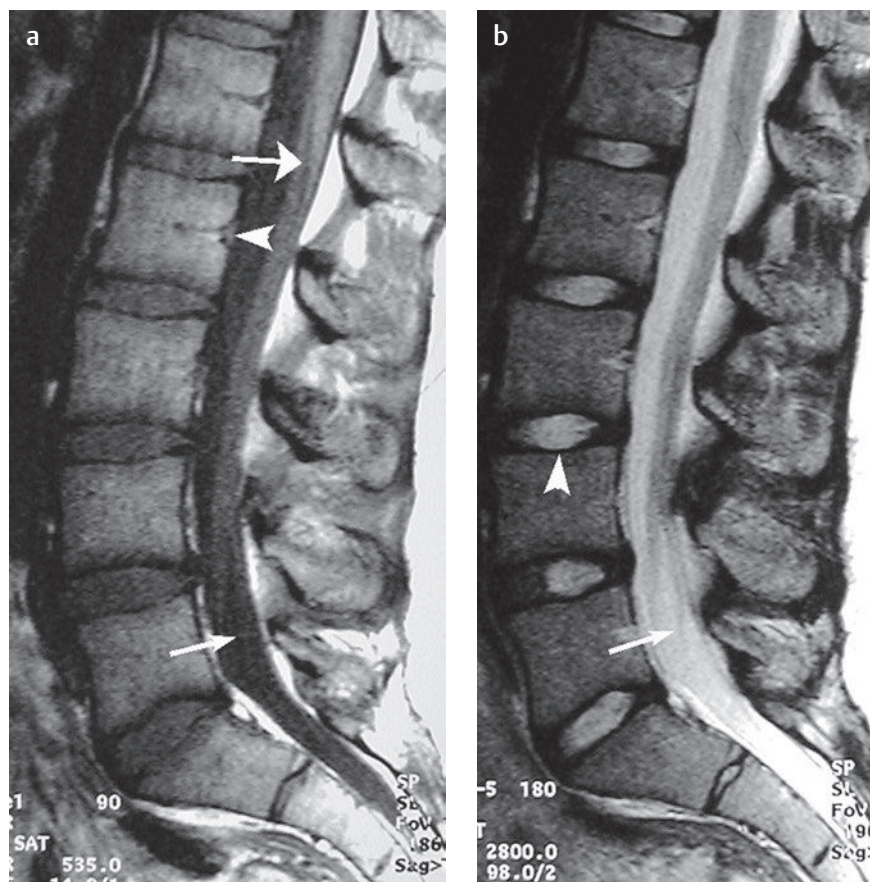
Normal lumbar spine in a 16-year-old girl. (a) A sagittal T1-weighted image shows dark CSF (arrow with small head), the conus medullaris terminating at the L1-L2 level (arrow with large head), and the basivertebral channel (arrowhead). Note the normal rectangular appearance of the vertebral bodies and the lumbar lordosis. (b) A sagittal T2-weighted image shows bright CSF (arrow) and a bright nucleus pulposus (arrowhead).
